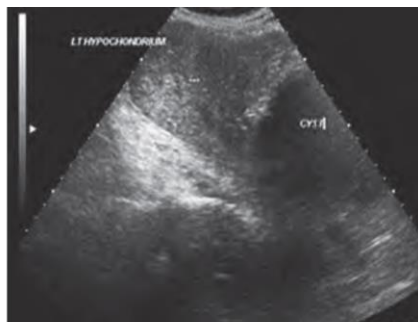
Sonography at left kidney injury. Urohematoma
